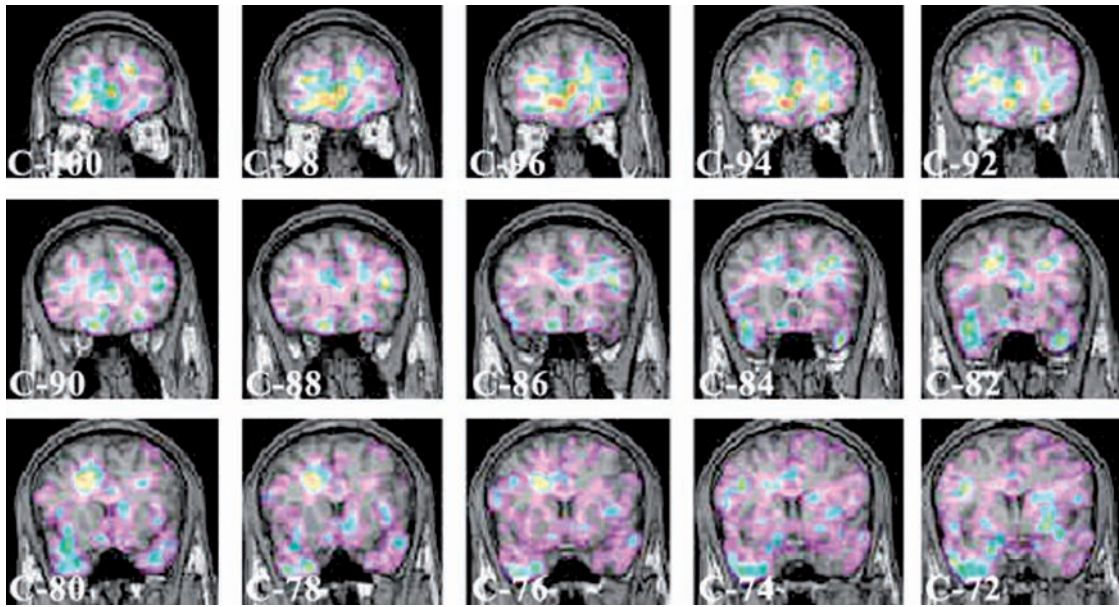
Ictal single-photon emission computed tomography (SPECT), interictal SPECT, and subtraction of these images localized the seizure focus mainly to the ACC in one patient and to a lesser extent the caudal cingulum bundle. *Used with generous permission from DW. Seo (Seo; personal observation).*
